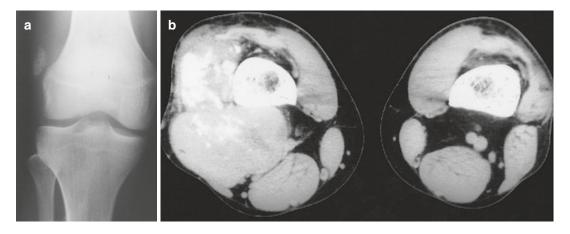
Synovial sarcoma arising in the vastus lateralis in a 66-year-old man. (a) Plain radiograph. (b) CT. Both imaging techniques demonstrate amorphous calcification
